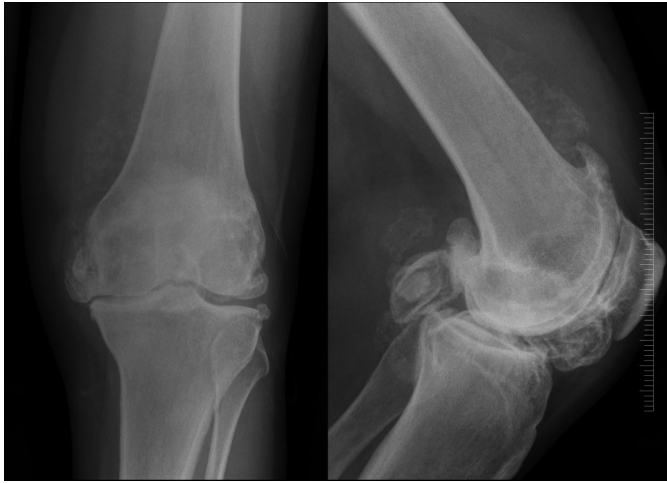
Preoperative Anteroposterior and Lateral Radiograph.
